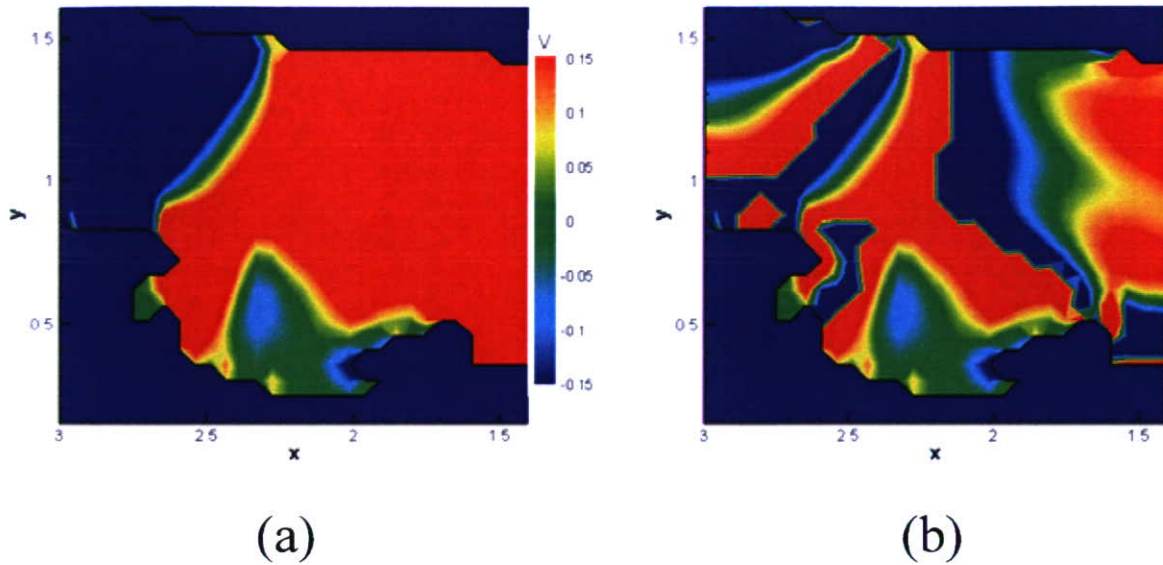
Comparison of (a) color Doppler image around an aneurysm at peak flow of standard solution without aliasing and (b) that with aliasing.
